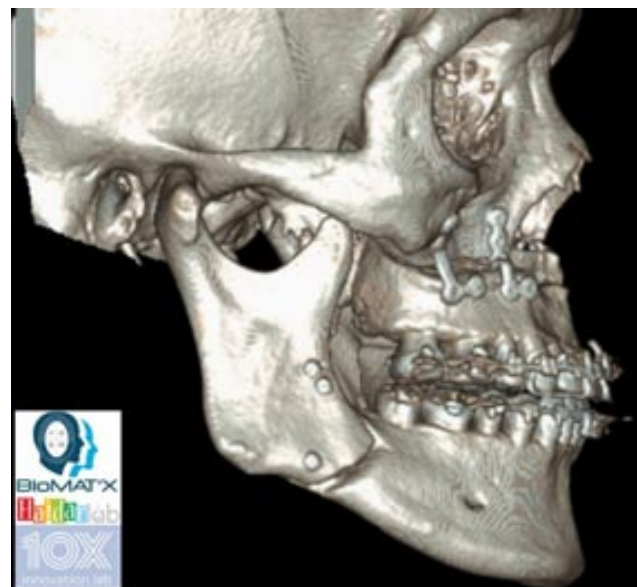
Immediate post-operative CT Scan showing very accurate positioning of the maxilla and the mandible when compared to the preoperative virtual surgical planning.
